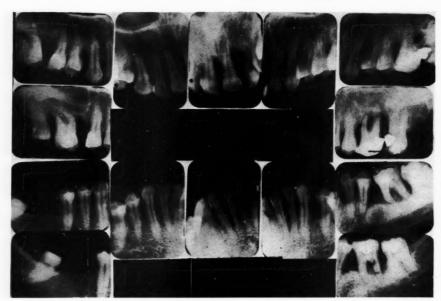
Intra-oral radiographs showing regions of 'vertical' bone resorption.
